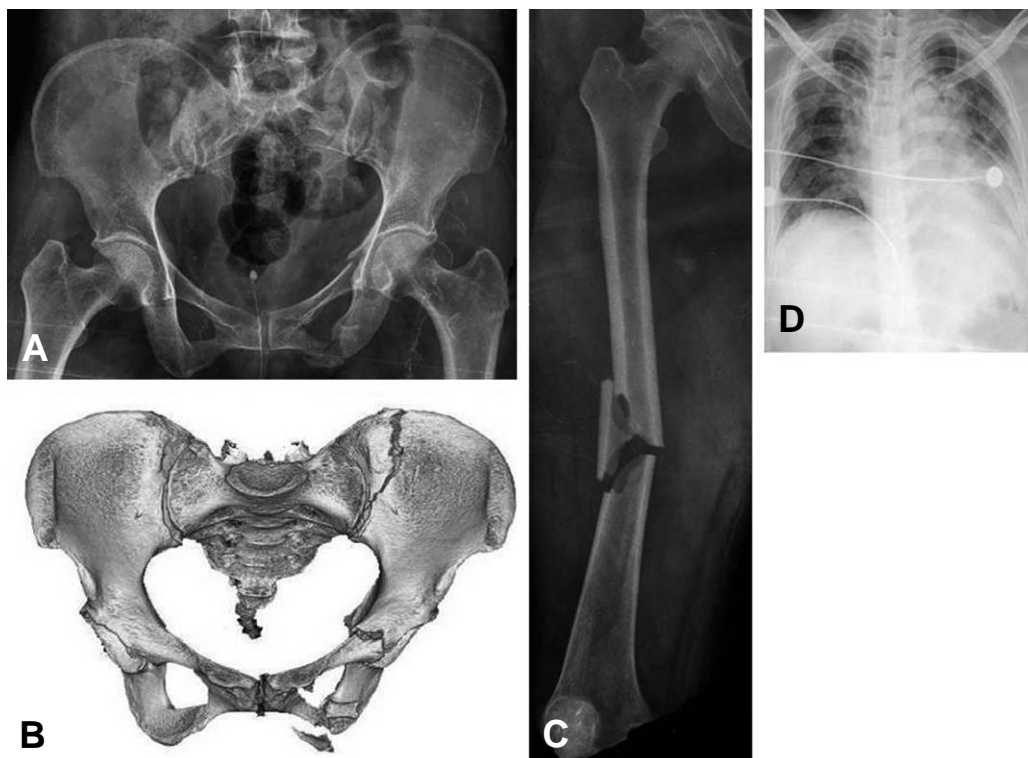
Simple radiography (A) and 3-dimensional CT (B) showing crescent fracture on left ilium and both superior and inferior rami fractures on left hemipelvis. There is also a fracture on right femoral midshaft (C). She suffered from lung contusion and multiple left rib fractures (D).
